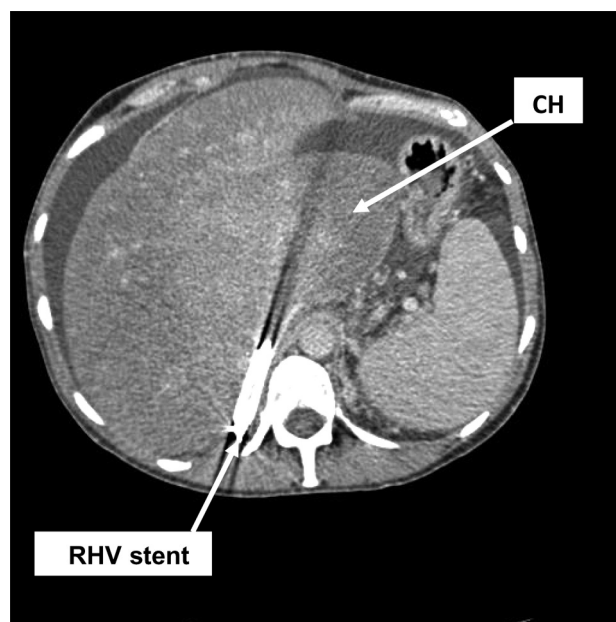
Contrast-enhanced CT post right hepatic vein (RHV) stent insertion. Caudate lobe hypertrophy (CH) is well demonstrated.
